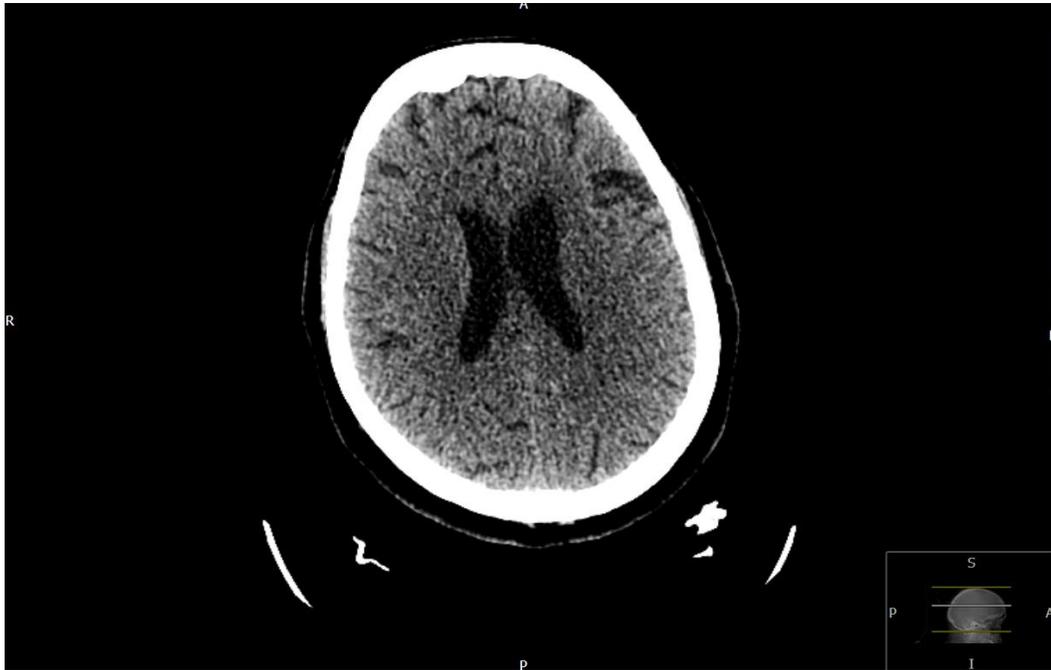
CT head on day 3. Patient developed right basal ganglion infarct.
